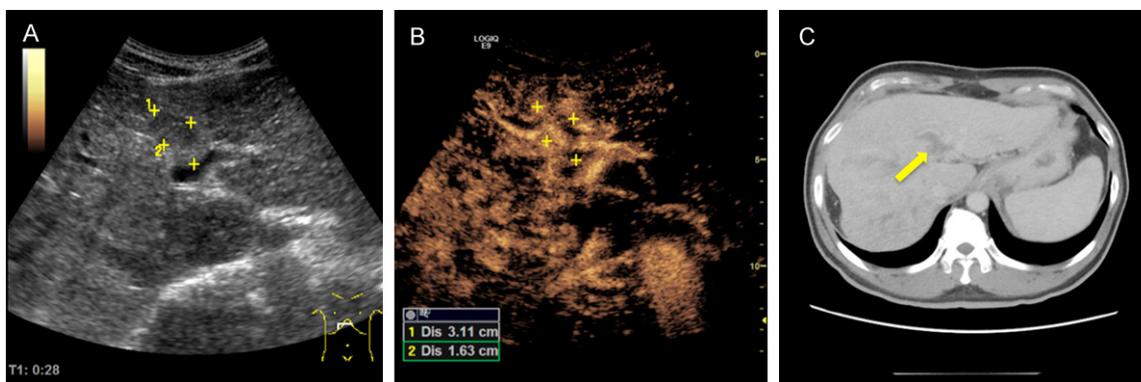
PVTT in sagittal section of portal vein. A: Conventional ultrasound imaging. B: CEUS imaging. C: Enhanced CT imaging.
